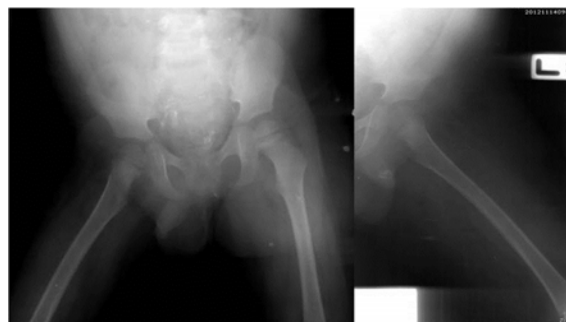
The radiographs of left femur showed mild soft tissue swelling without bony lesion.
